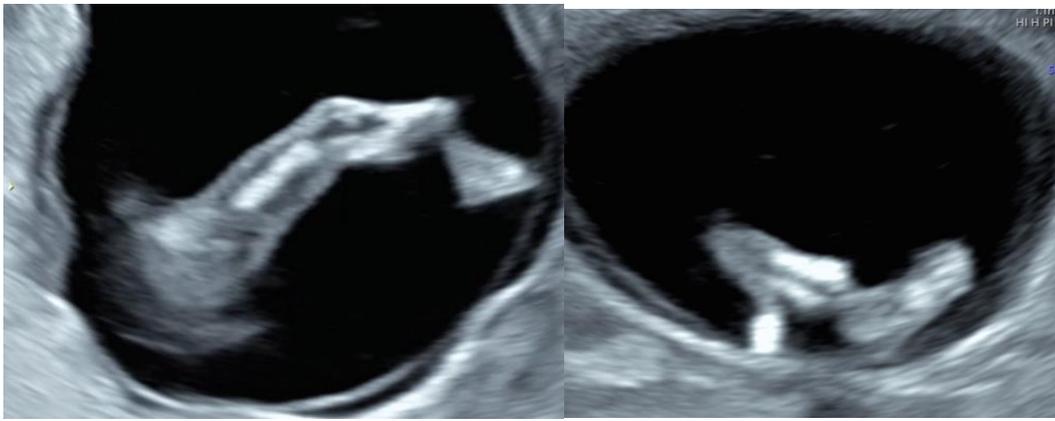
(a,b,c,d). 2D Ultrasound images showing fetal right leg with fractured appearance at its distal end, short tibia and fibula and hanging foot
